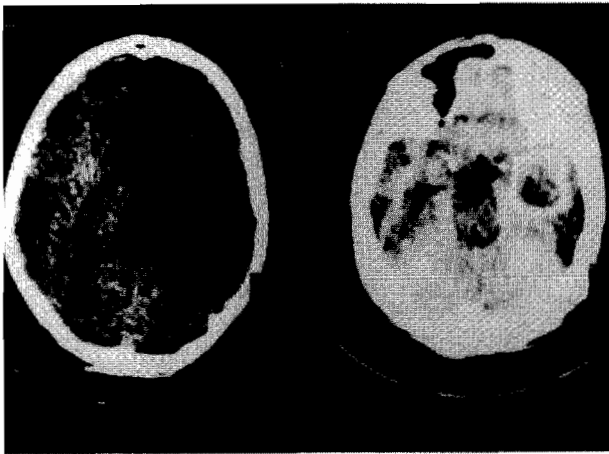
Pre-and post contrast axial brain CT scans showing a well demarcated encapsulated intracerebral abscess in the left temporoparietal lobe. The capsule of the abscess shows brilliant ring enhancement after contrast injection. The surrounding brain is hypodense due to oedema.
